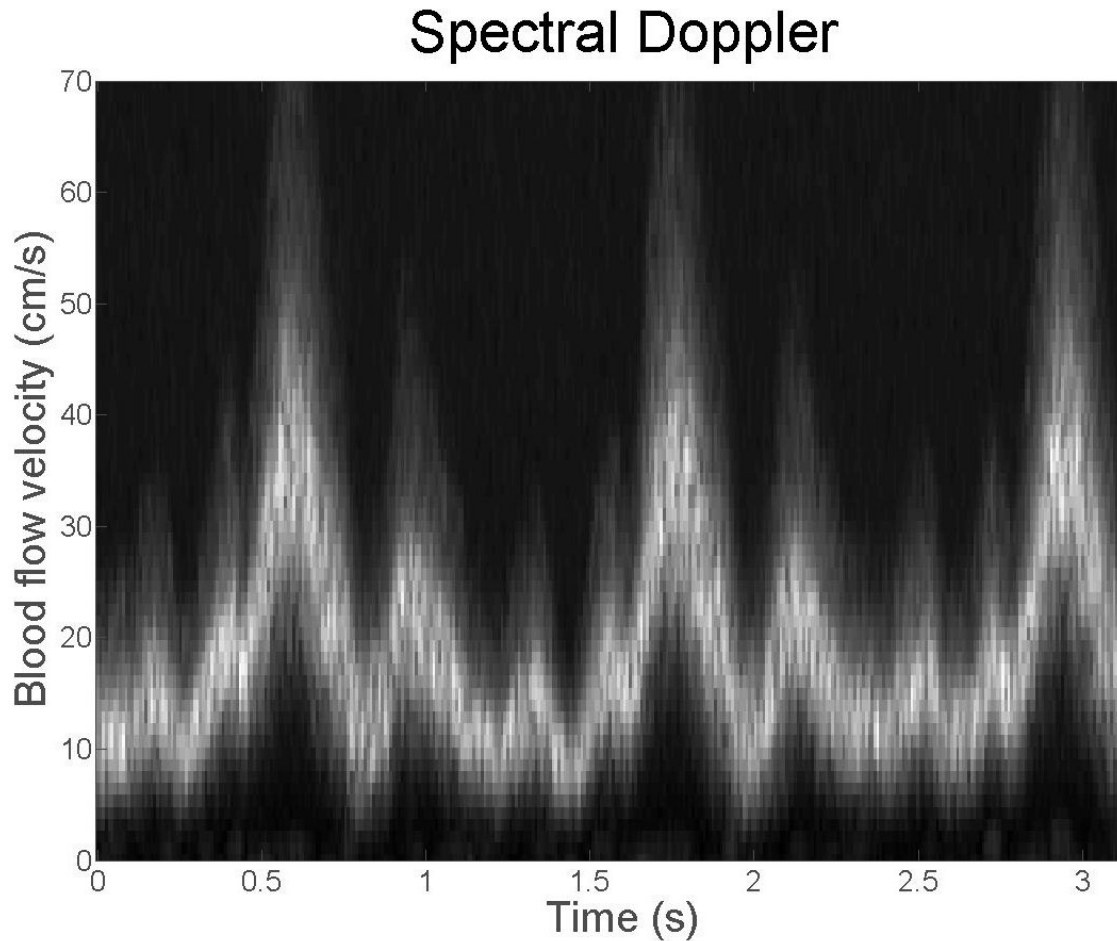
Spectral Doppler data of the jugular vein blood flow. Subject #8.
